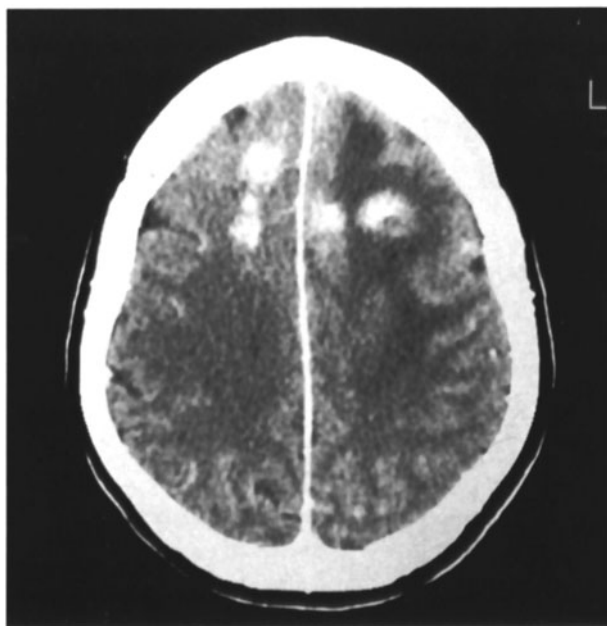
Apparent multi-centric growth of glioblastoma on magnetic resonance imaging (MRI)
